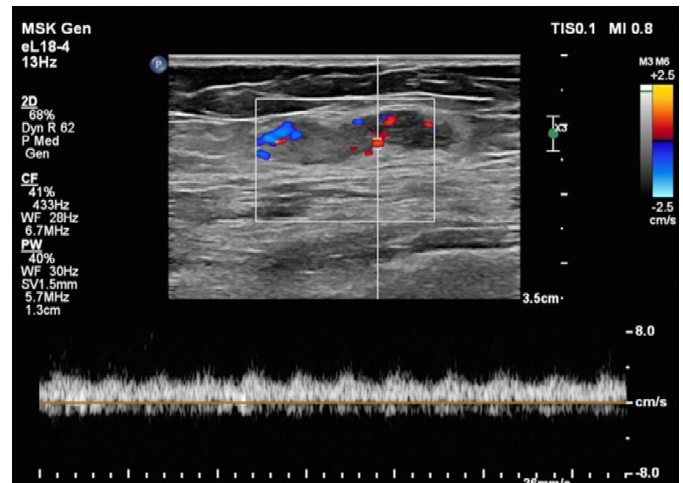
Doppler Study showing venous malformation
